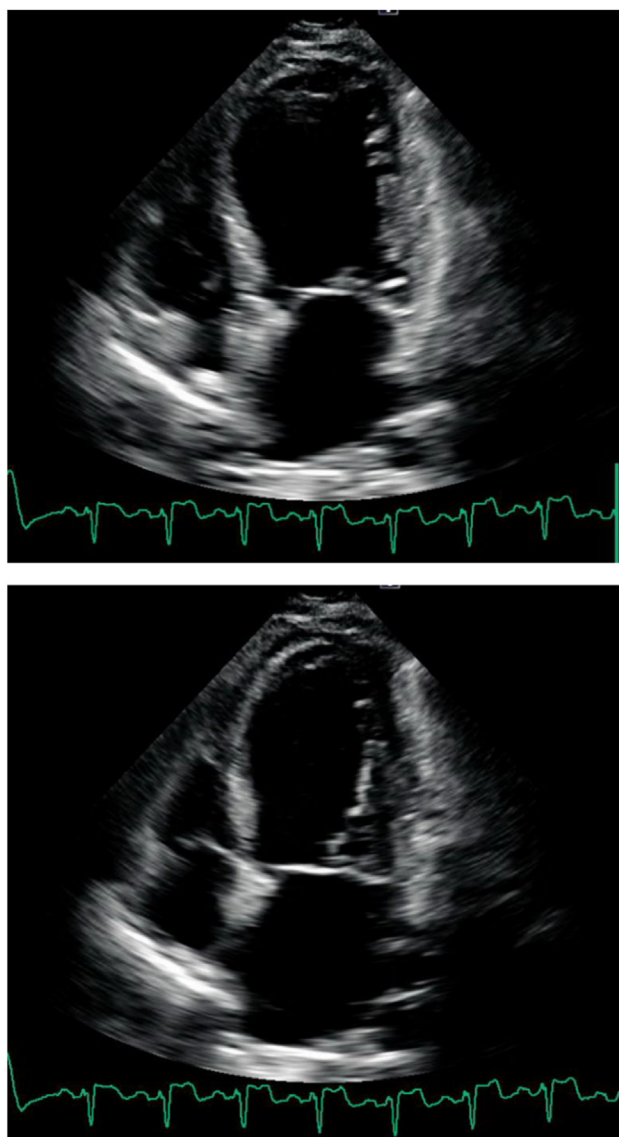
Preoperative two-dimensional TTE, apical 4-chamber view, in end diastole (*top*) and end systole (*bottom*), demonstrates the dilated LV and left atrium with reduced LV systolic function.
